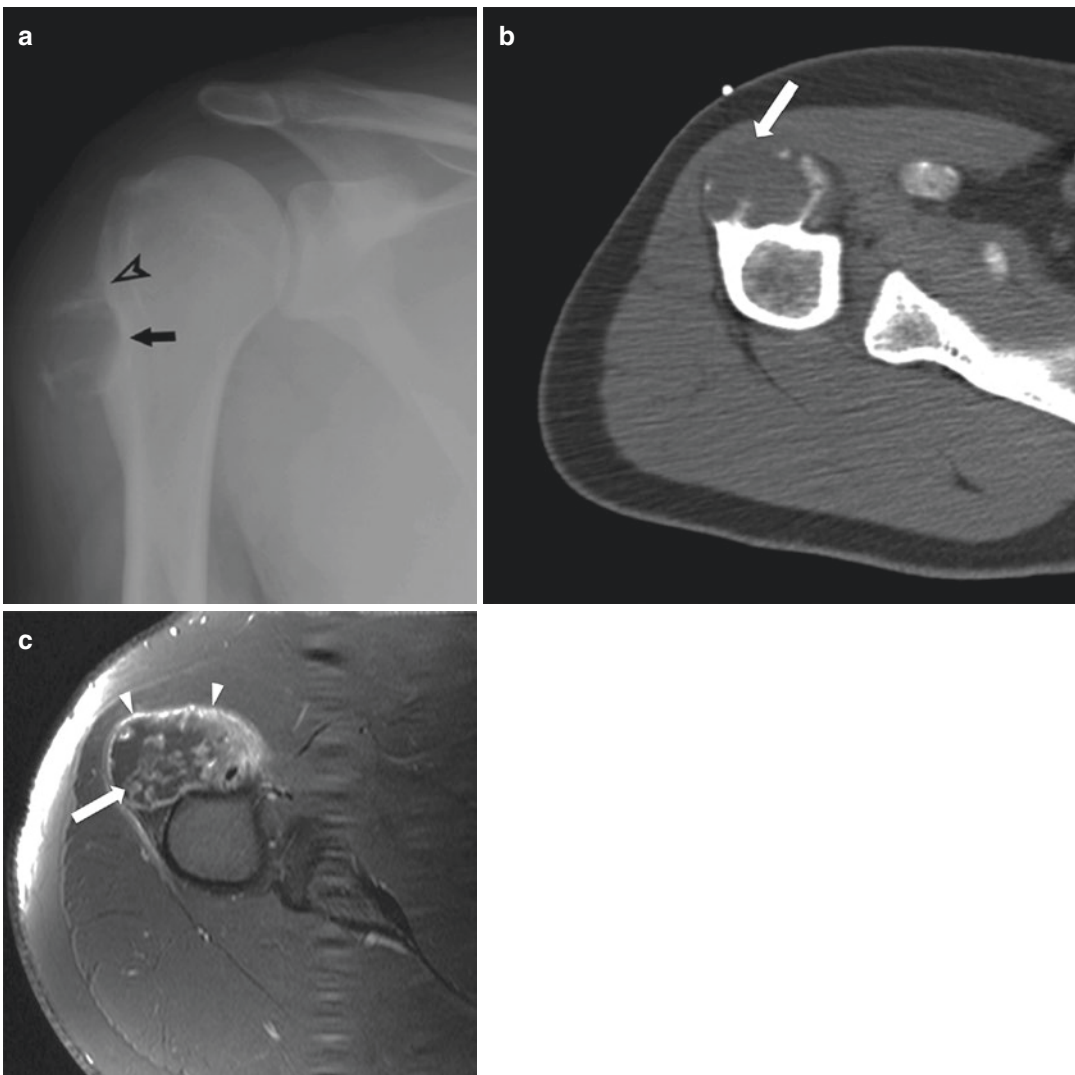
Periosteal chondroma: 19-year-old male with anterior lateral right-shoulder lump for 11 months. Radiograph (a) reveals a juxtacortical lesion. There is mild saucerization (arrow) and partial cortical shell. Cortical buttressing is present at the lesion edges (arrowhead).
